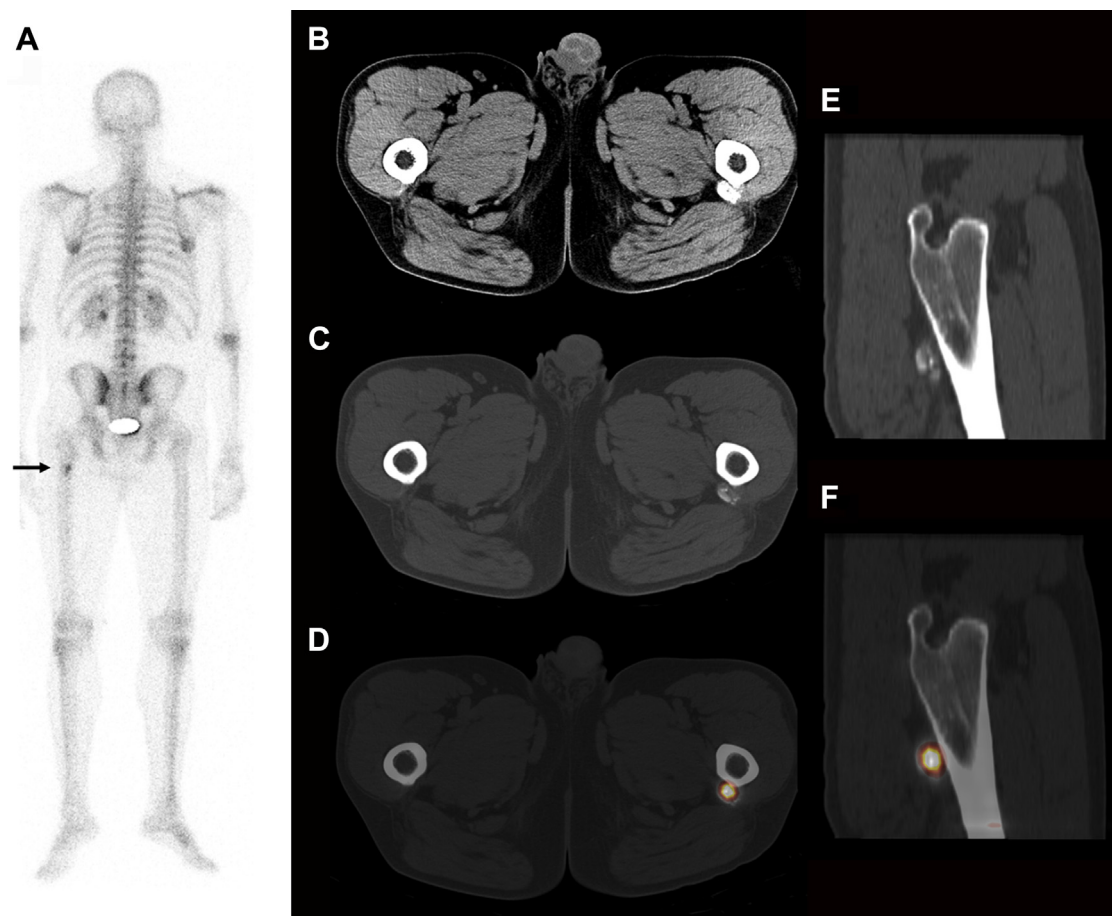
Acute pain. Posteroanterior whole body scan (A), axial CT slices (B, soft tissue window, C, bone window), and hybrid SPECT/CT slices (D), sagittal CT (E), and SPECT/CT (F) slices in a 52-year-old man with acute pain in the left hip. The whole body scan shows a hot spot (arrow) at the insertion of the gluteus maximus muscle on the gluteal line of the left femur. SPECT/CT shows this avid tracer uptake localizes in hydroxyapatite deposition at the insertion. SPECT/CT, single-photon emission computed tomography/computed tomography.
